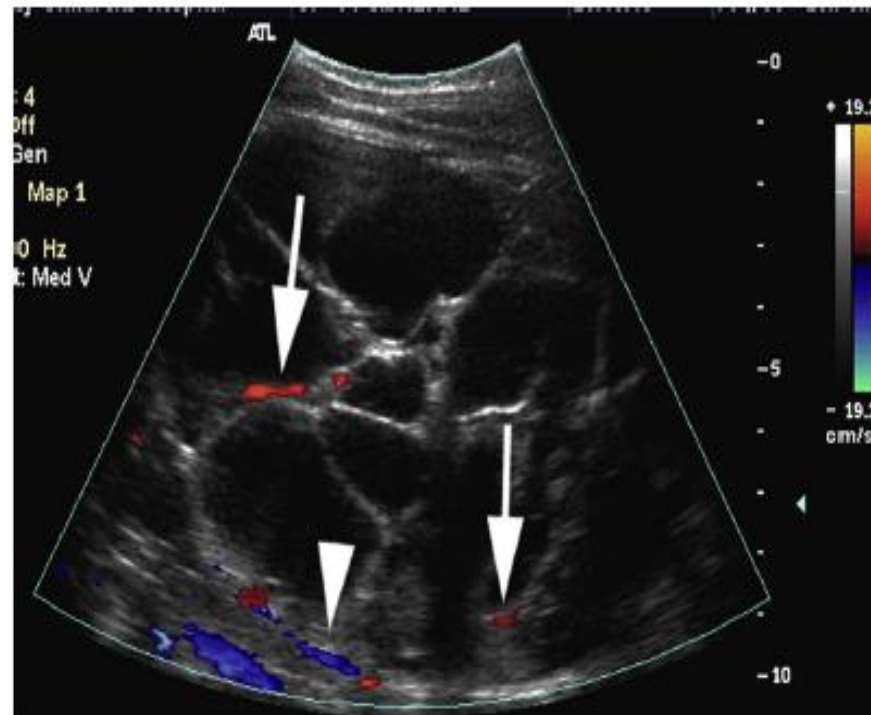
Figure Longitudinal color doppler US of a complex (grade III by both radiologists) left renal cyst in a 7.2 year-old boy. The child presented with gross hematuria. Ultrasound shows a septated cystic mass with vascularity of the septations (arrowheads) and cyst wall (arrow). Radical nephrectomy was performed with pathologic diagnosis of multiloculated cystic nephroma.
